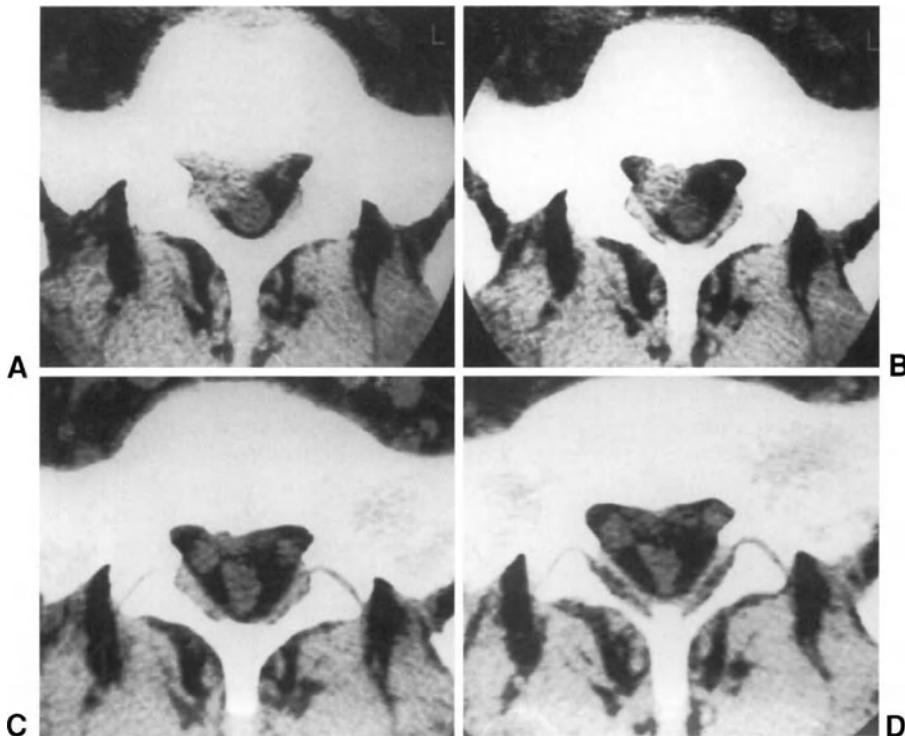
(A) and (B) Axial CT scans of a patient with disc herniation migrated distally to the L5-S1 disc on the right. (C) and (D) CT scans at the same levels obtained 1 year after the previous examination. Complete disappearance of the migrated fragment. Only a slight paramedian bulging of the L5-S1 disc is visible on the right.
